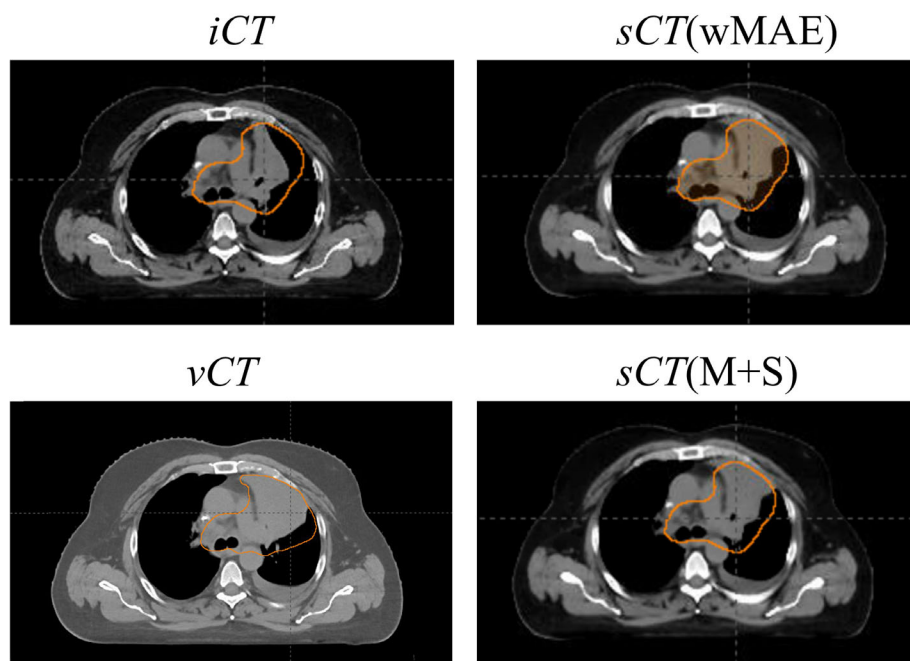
Comparison of one CT slice in the middle of CTV among the *iCT*, *vCT*, and *sCT*s of a case with a relatively poor performance from our proposed methods (the 10th testing patient in Table 3), where the circle highlights the CTV in each subfigure.
